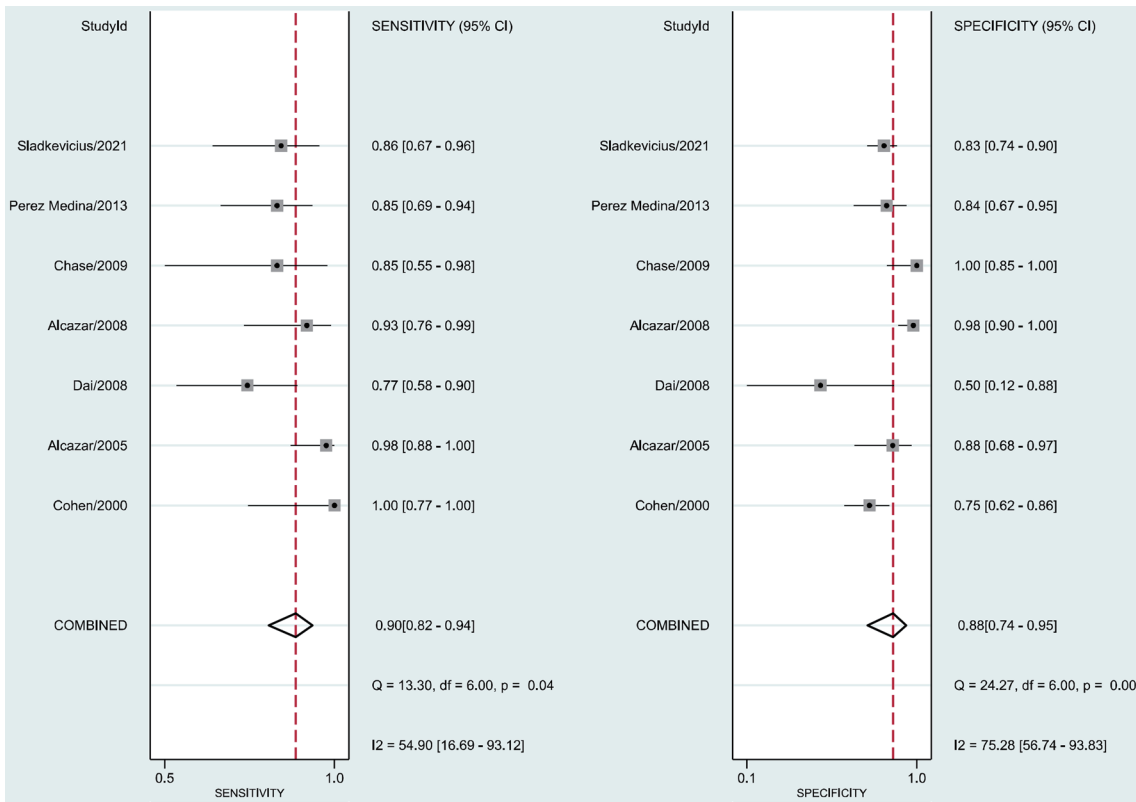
Forest plot for sensitivity and specificity for 3DPD assessment of tumor vascular tree in studies including only “complex” or “suspicious” adnexal masses. CI, confidence interval; 3DPD, three-dimensional power Doppler.
